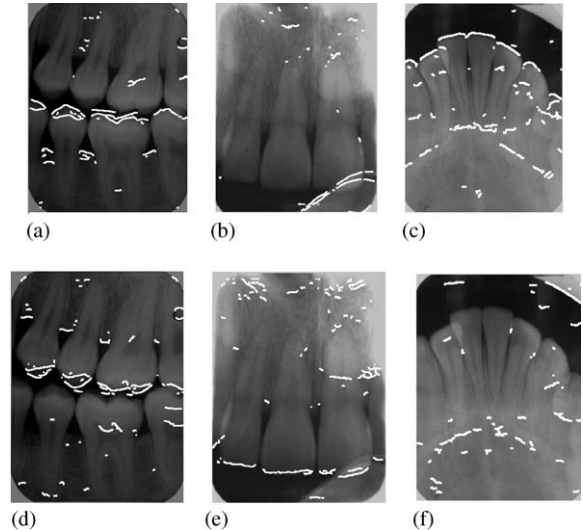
Horizontal edges with upward gradient in (a) bitewing; (b) upper periapical; (c) lower periapical. Horizontal edges with downward gradient in (d) bitewing; (e) upper periapical; (f) lower periapical.
